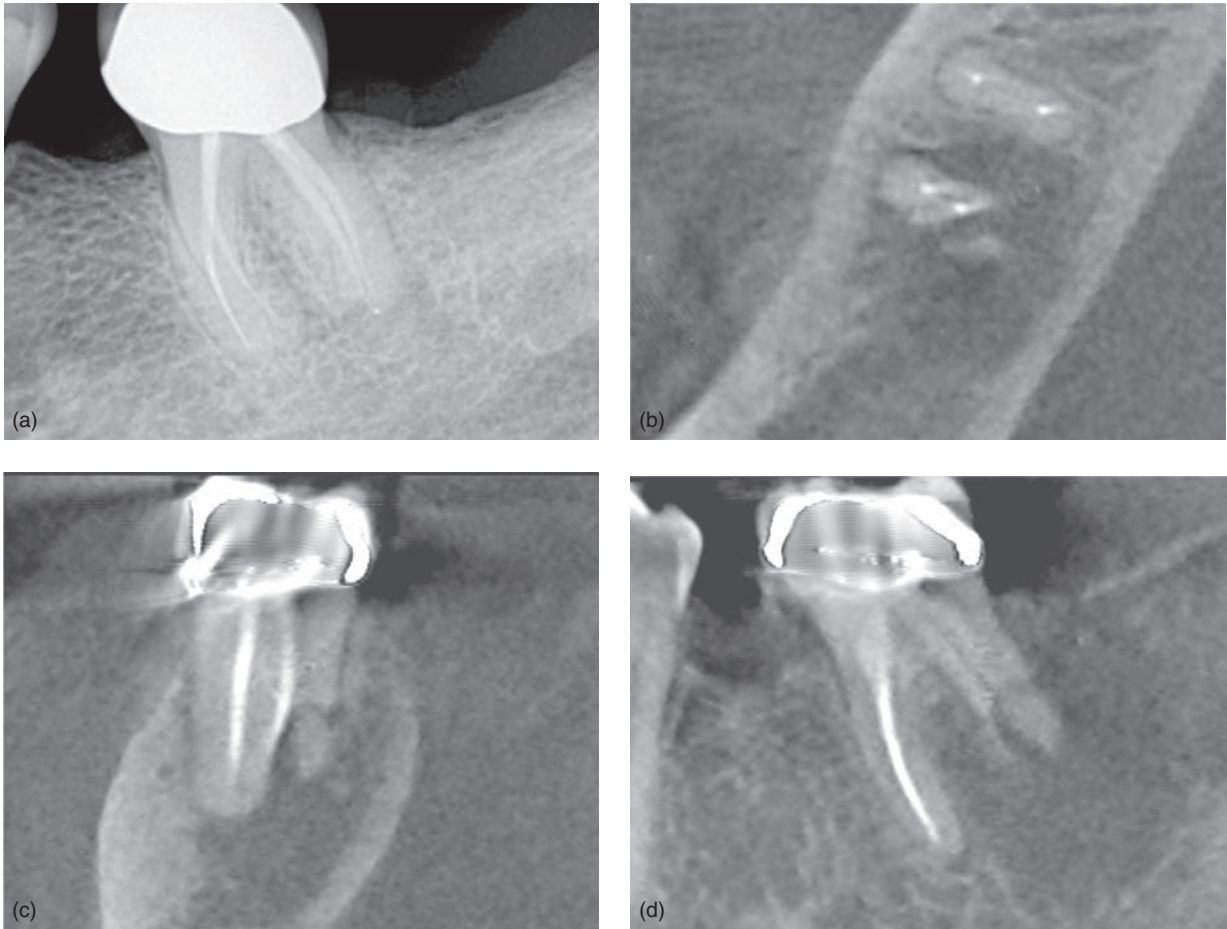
Previously treated mandibular molar with a separated file. (a) Periapical radiograph; (b), (c), and (d) axial and coronal views. A distal root fracture was identified on CBCT images that the periodical preop radiograph did not show. Therefore, extraction was opted.
